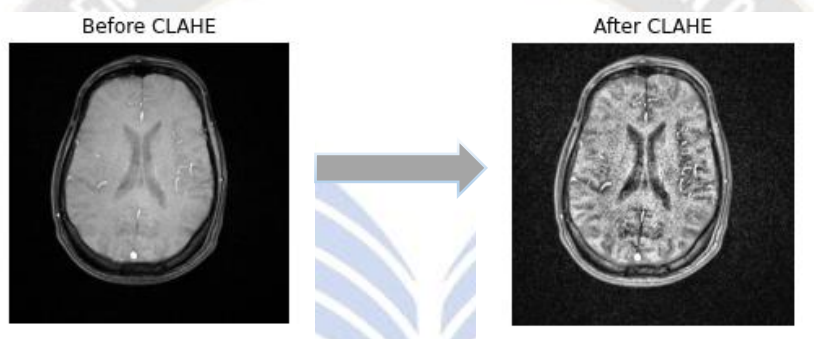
Enhanced sample MRI image using CLAHE
